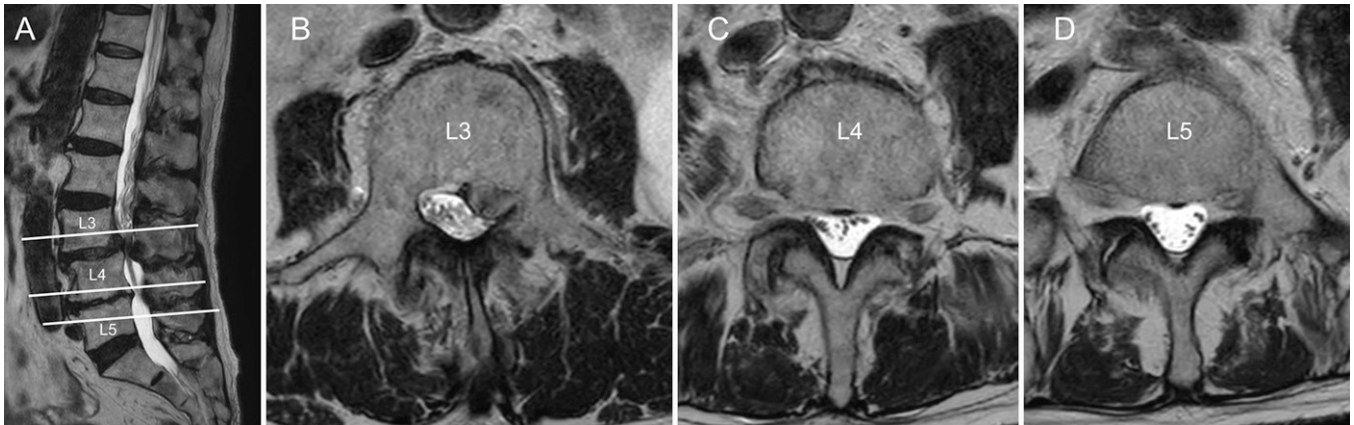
Initial spinal cord MRI. Sagittal T2-weighted image (A) shows severe disc herniation at L3–4 and severe lumbar spinal canal stenosis at L3–4 and L4–5. Axial T2-weighted images (B–D) at the levels of the white lines in panel A.
